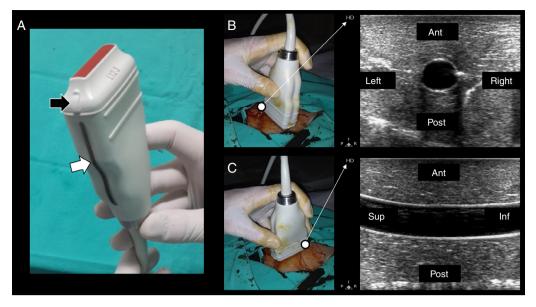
(A) Lineal transducer. The transducer indicator is in this case represented by a salient (black arrow) and a dark-gray line (white arrow). This indicator demarcates the beam leading edge that corresponds to a mark on the screen (in this machine, "HD" in B and C). (B) In the short axis, the probe indicator is pointing toward the operator's left side, matching the left side of the ultrasound machine screen. In this axis, the vessels are shown round (arteries) or oval (veins). (C) Starting from the short axis, the transducer is rotated 90 degrees clockwise, thus obtaining the vessel long axis. The probe indicator is located furthest from the operator (Sup.) and matching, again, the screen left side. In this axis, the vessels appear tubular. Ant.: anterior; Post.: posterior; Sup.: extreme of the transducer furthest from the operator; Inf.: extreme of the transducer close to the operator.
